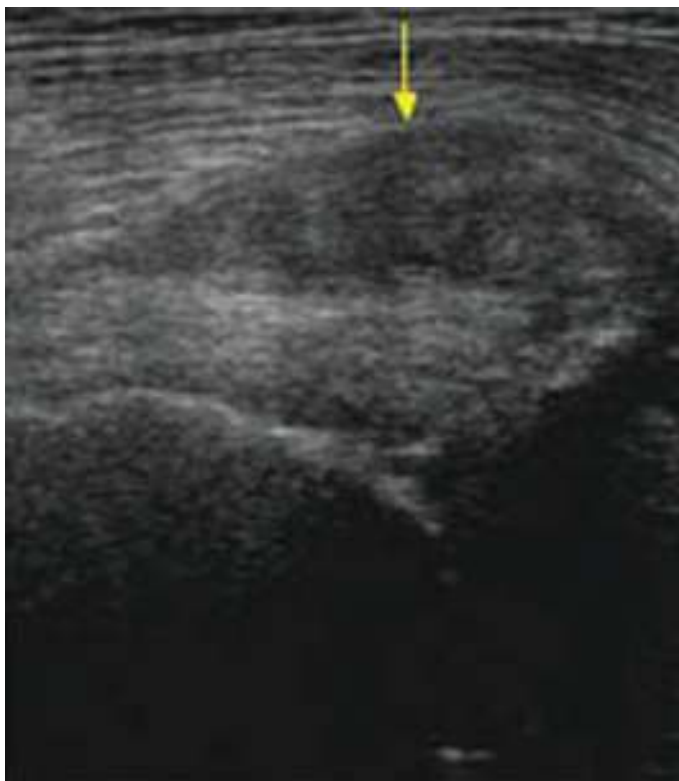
US image of ischial bursitis. Note the mixed echogenicity in the enlarged bursa (arrow). (US image courtesy of www.ultrasoundcases.info.)
